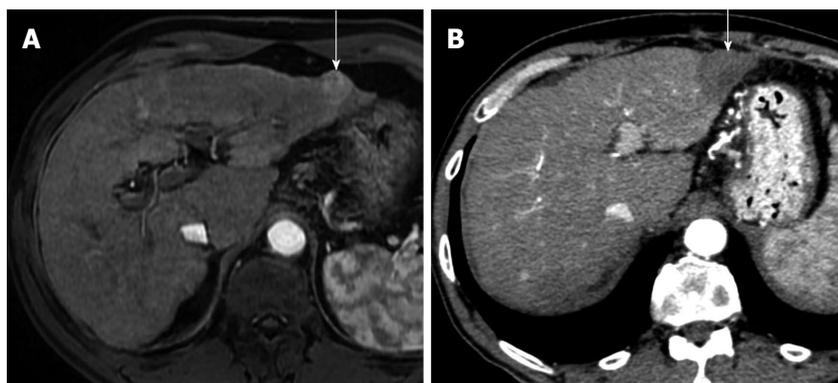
Successful hepatocellular carcinoma resection with radiofrequency tissue coagulation device. A: Pretreatment arterial phase T1-weighted gradient-echo magnetic resonance shows hypervascular hepatocellular carcinoma (HCC) (arrow); B: On arterial phase computed tomography obtained 4 mo after treatment no hypervascular focus is evident (arrow). Note that resected area is larger to preexisting HCC.
